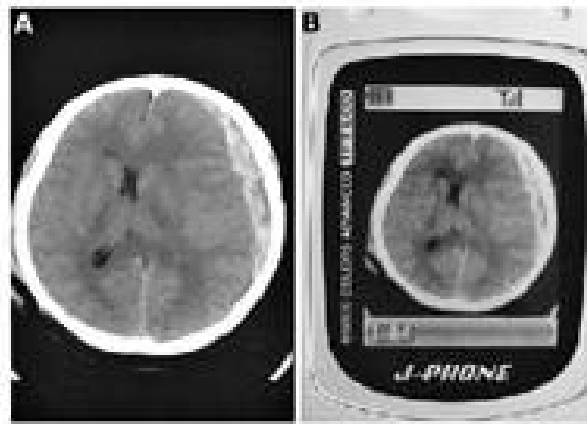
A*, original CT scan of acute subdural hematoma. *B*, mobile phone-transmitted image.
